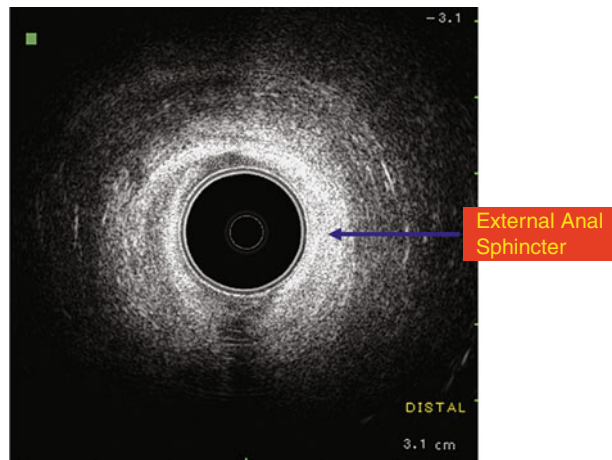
Distal anal canal. Normal distal anal canal, as it appears on endorectal ultrasound. Note that only the external anal sphincter and surrounding soft tissues can be seen
